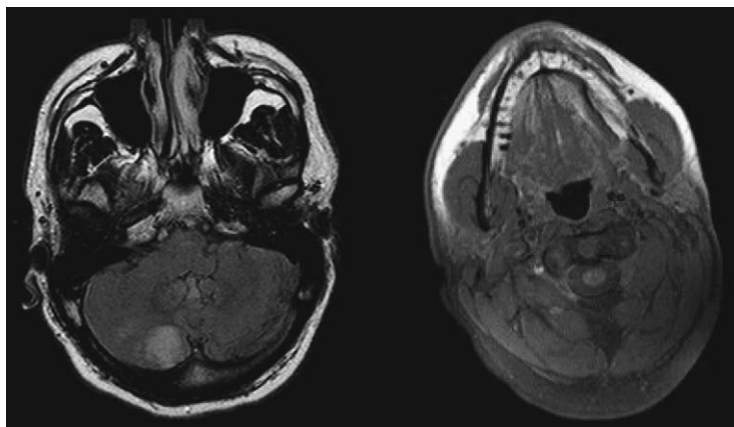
The axial MRI on the left shows small areas of restricted diffusion in the right inferior cerebellum, indicating an acute right anterior inferior cerebellar artery (AICA) territory infarct. Signal changes in the right vertebral artery seen in the second image are consistent with thrombosis and dissection. This elderly patient presented with acute onset vertigo and ataxia.
